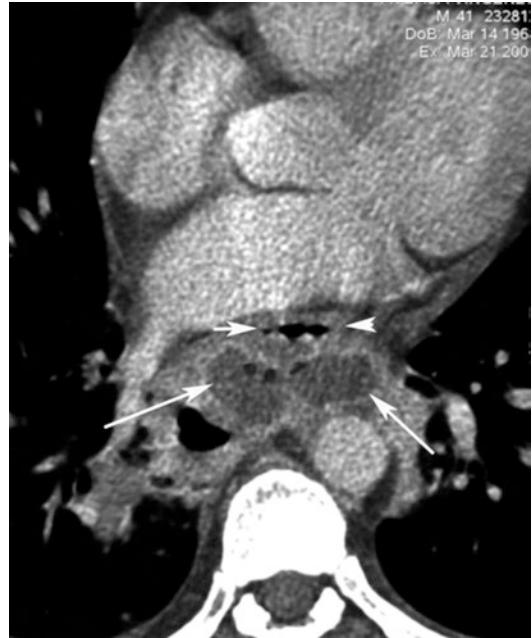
Post-contrast CT axial image at the level of inferior mediastinum shows a mediastinal fluid collection (white arrows) mixed to air bubbles, posteriorly to the oesophagus (white arrow heads), due to oesophageal injury and perforation
